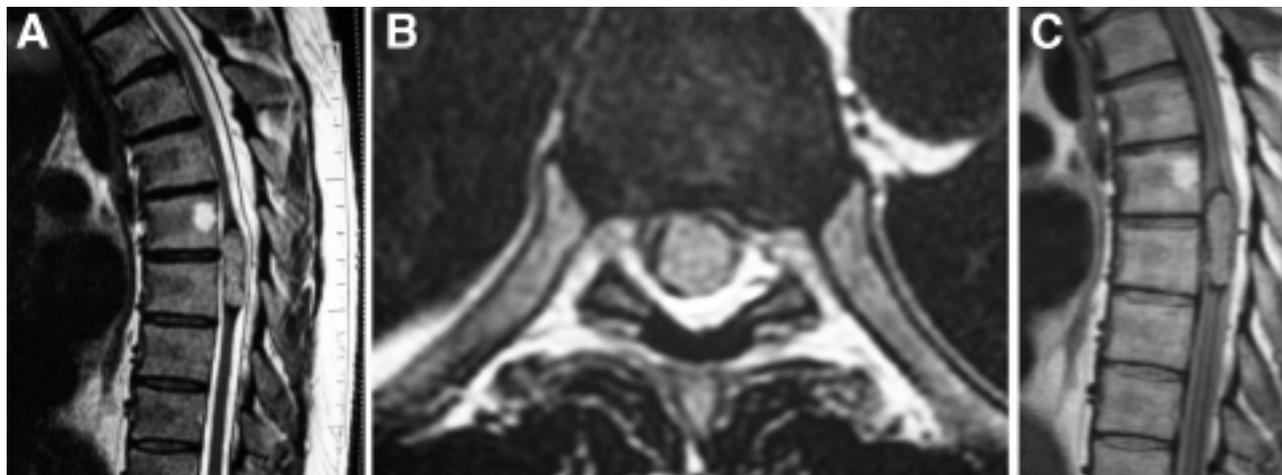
Case 26. Preoperative MR images of an intramedullary CM with a chronic presentation. *A:* Sagittal T₂-weighted image revealing the intramedullary lesion with hemosiderin ring. *B:* Axial T₂-weighted image confirming the intramedullary location and width of the minimally expanded spinal cord. *C:* Sagittal T₂-weighted image also demonstrating hemosiderin and blood products extending up the central canal.
